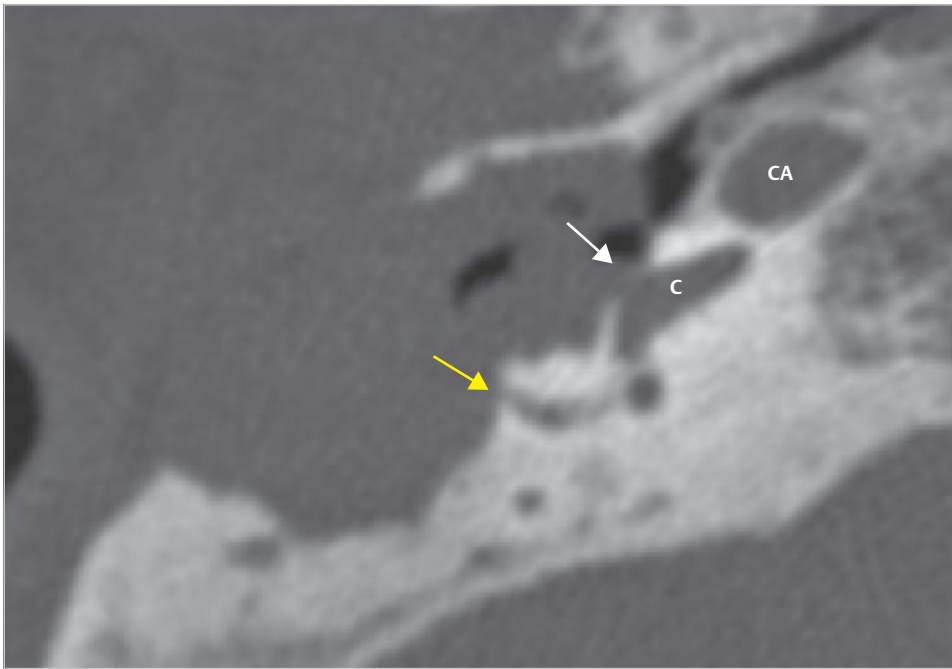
The axial CT shows presence of large labyrinthine fistulae in both cochlea (*white arrow*) and the lateral semicircular canal (*yellow arrow*). In spite of presence of these large fistulae, the patient maintained decent bone conduction. Since the contralateral ear shows mixed deafness due to tympanosclerotic change, preservation of the inner ear function in this ear is indicated. Total deafness is mandatory if the skin covering the cochlear fistula is removed. C, cochlea; CA, carotid artery.
